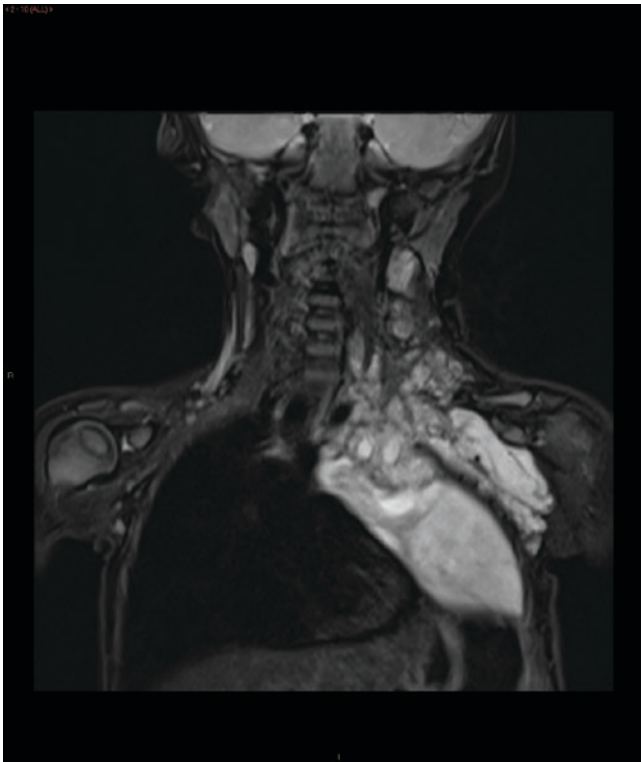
Extensive lymphatic malformation. Coronal T2 STIR MR image of the neck and chest shows a large, infiltrative lymphatic malformation involving the left side of the neck, axilla, and left side of the thorax
